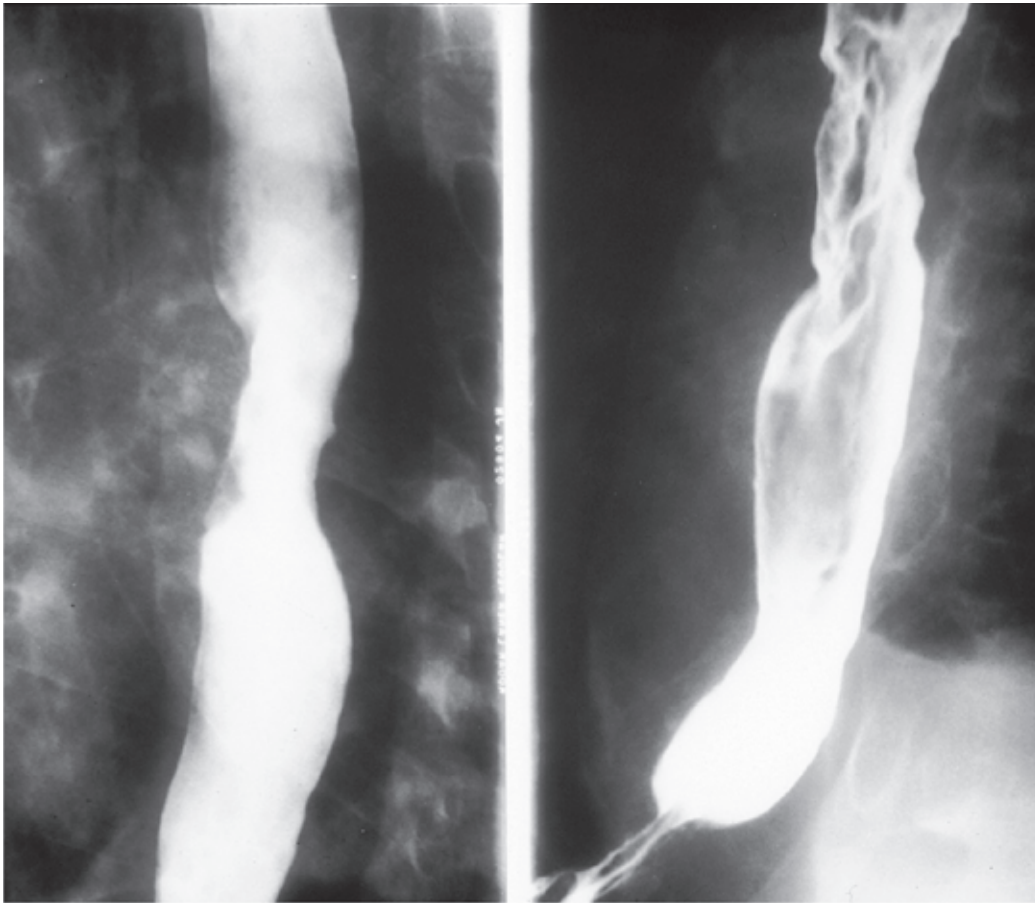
Barium contrast swallow study of the esophagus. X-ray of barium column in the esophagus showing narrowed area (*center of left image*) suggestive of an esophageal tumor (*left*). Following passage of the bulk of the barium, a coating of contrast medium outlines the mucosa, demonstrating irregularity and constriction as a result of esophageal cancer (*right*).
